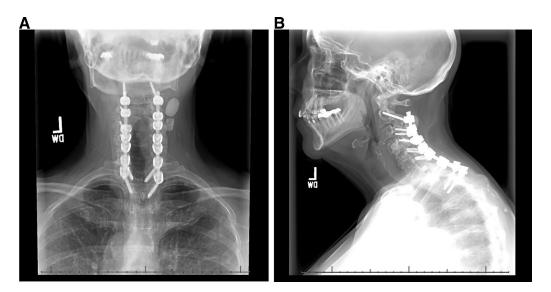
A, 4B Post-operative AP (4A) and Lateral (4B) view radiographs demonstrate intact hardware without evidence of failure.
